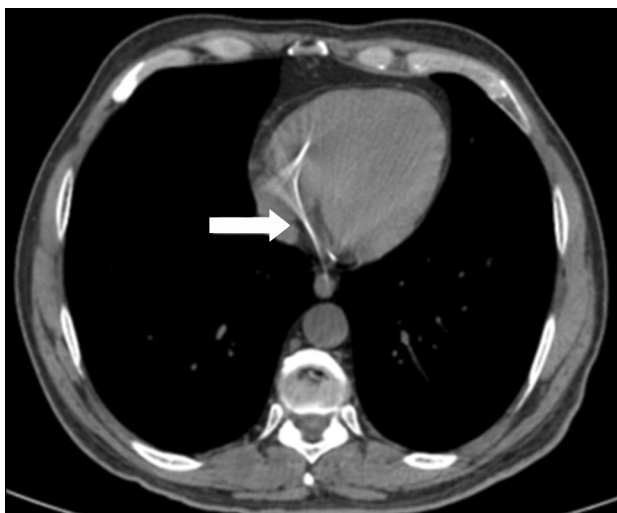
Part of a fractured catheter is seen in the heart on a computed tomography scan (arrow).
